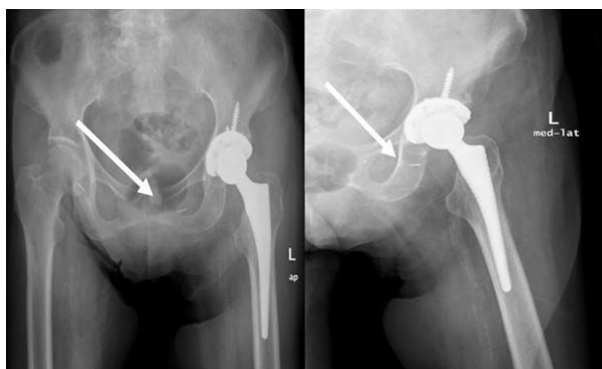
Post-operative radiograph showing a cemented Total hip replacement and two foreign bodies below the left hip and pubic tubercle
